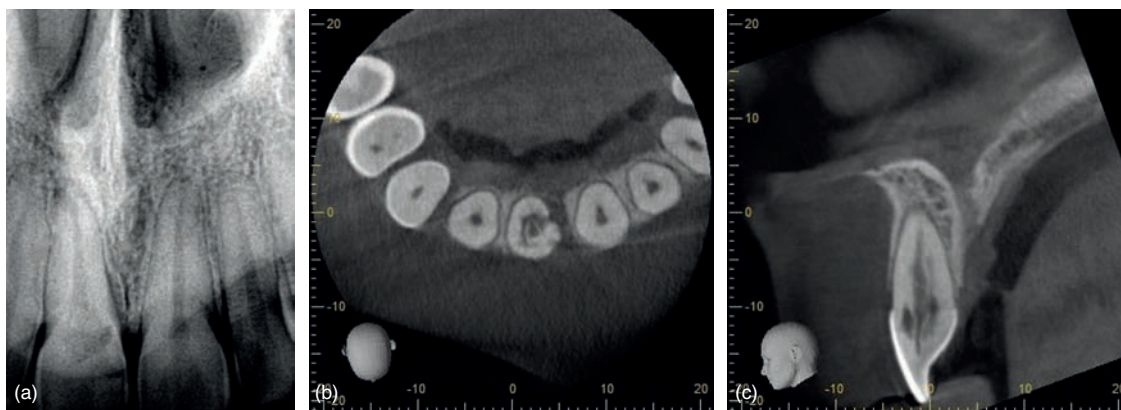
Cervical resorption. (a) Periapical radiograph showing the maxillary right incisor with cervical radiolucency indicative of resorption. (b) Axial view. (c) Coronal view shows advanced external root resorption. Due to the extent of the resorptive defect, endodontic treatment could not be performed.
